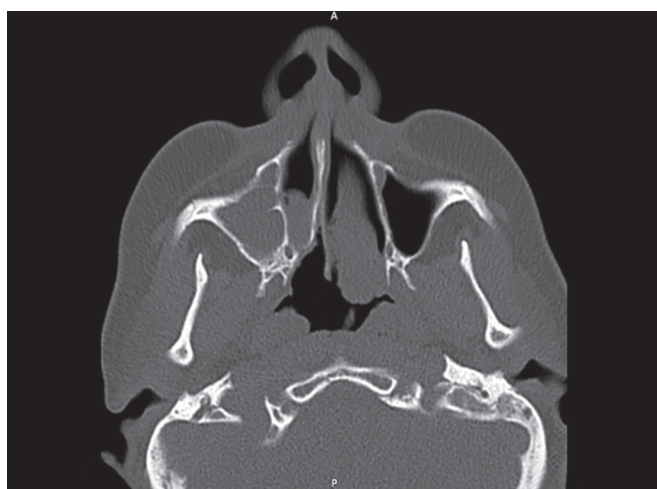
Axial CT scan shows right-sided unilateral choanal atresia. Note the inflammatory thickening of the right maxillary sinus mucosa and the narrow nasal cavity on the atresia side due to thickened pterygoid plates
